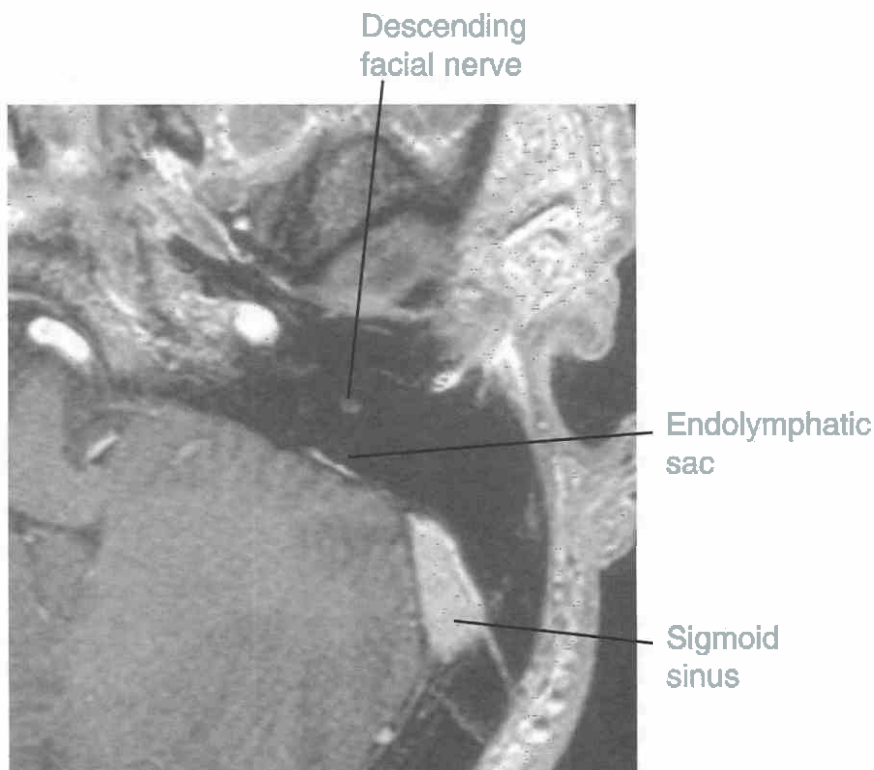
Endolymphatic sac inflammation in a young male who presented with severe hearing loss and vertigo, probably related to a viral infection. This is an axial 3D Fourier transform T2-weighted, high-resolution MR image through the descending facial nerve and the lower endolymphatic duct. Note the abnormal enhancement of the sac. Unlike a congenital anomaly or a tumor, the sac is not enlarged. This type of finding suggests an inflammatory process and has been described in association with Meniere's disease.
